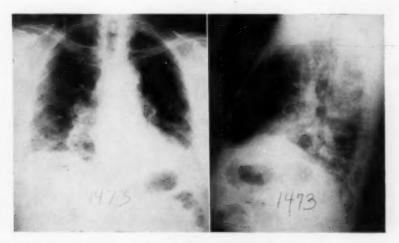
Chest roentgenogram of a 66 year old man with pulmonary fibrosis of unknown etiology. The total lung capacity was 56.0 per cent of normal predicted. Residual air was 22 per cent of total lung capacity.
